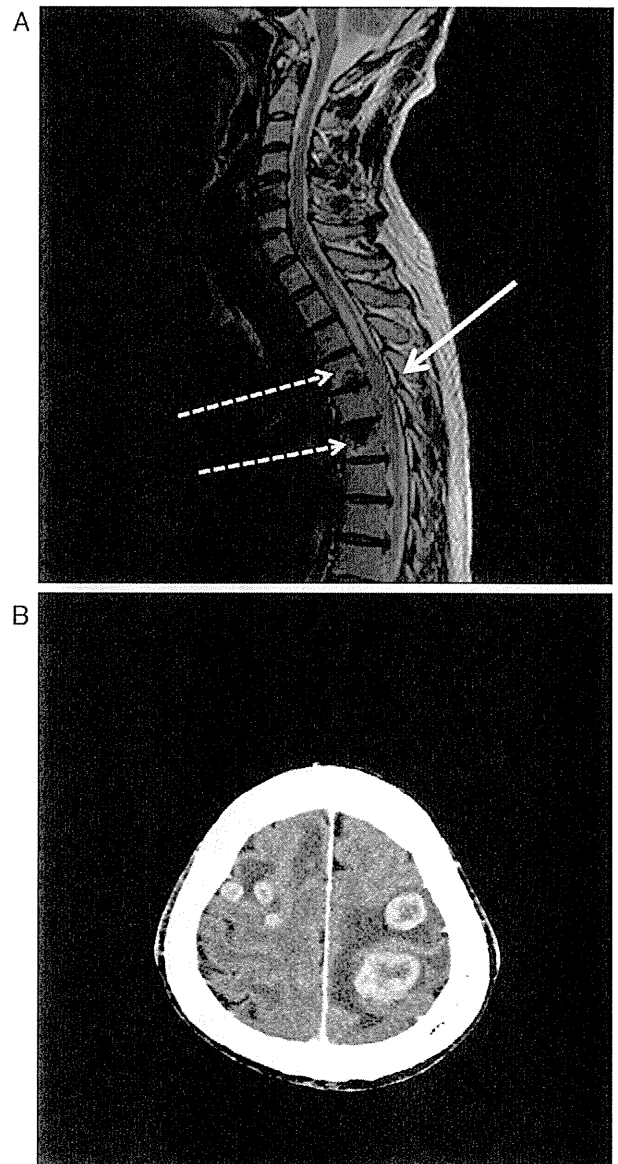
MRI (Case 1) of the spinal cord on 04/05/2010 shows the metastases to the spinal cord (straight allow) and the spinal column (Th 4,6 dotted allow). B. CT scan (Case 1) of the brain on 04/05/2010 shows multiple brain metastases.
